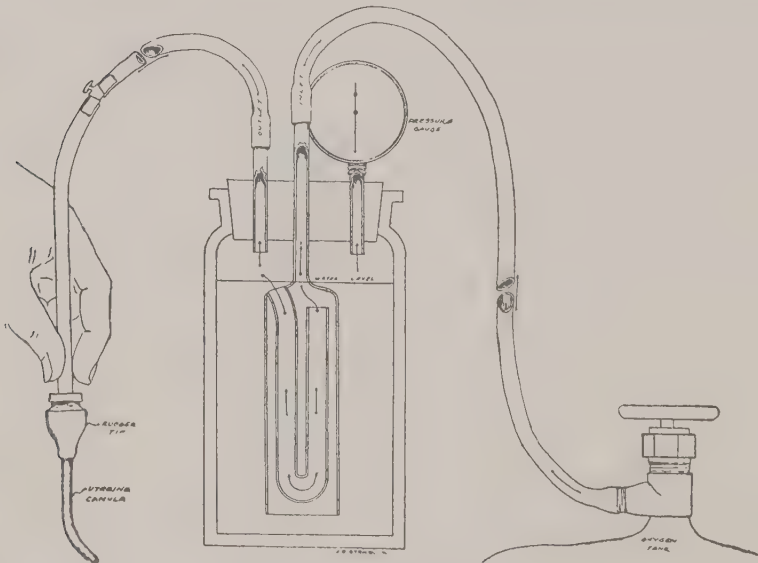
Newer apparatus for insufflating gas through tubes. (Rubin—*Am. Jour. Roentgenology*.)
